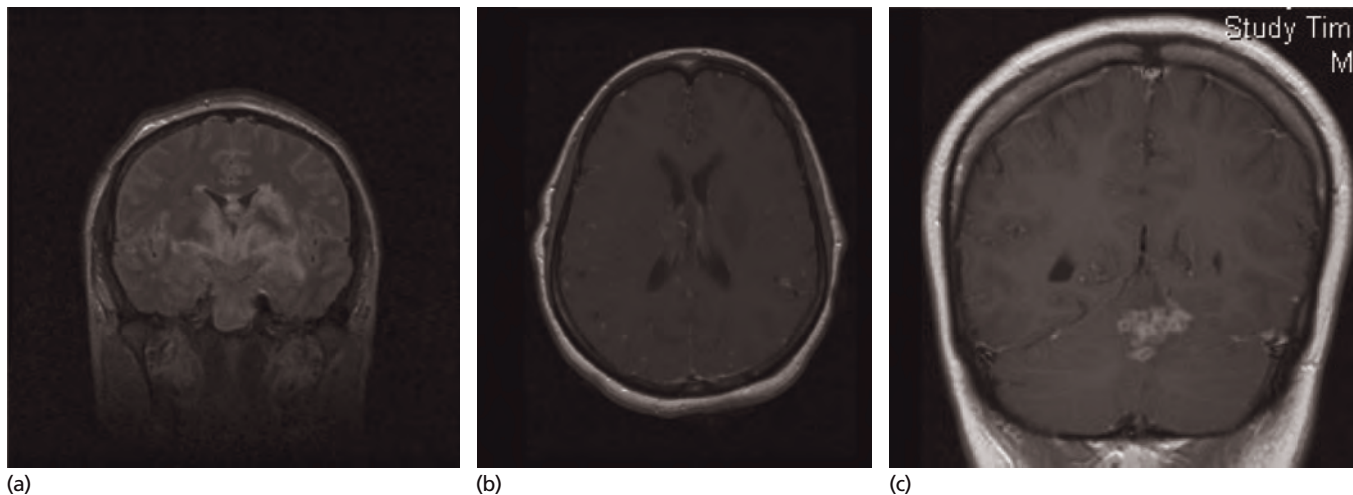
(a) Extensive vasculitis associated with tuberculous meningitis (MRI T1W). (b) Multiple tuberculomas (MRI T1W). (c) Multiple tuberculomas (MRI T1W).
